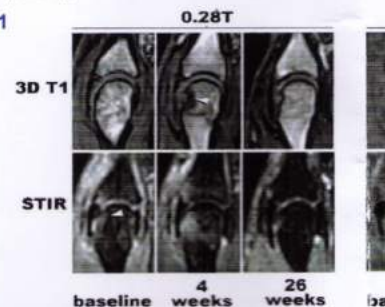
MRI of the second metacarpal phalangeal joint shows progressive development of a marginal osteitis at baseline and 4 weeks, and resolution of osteitis by 26 weeks. The conspicuous osteitis is more clearly visible on the 0.28T 3D T1 sequence with fat suppression.
